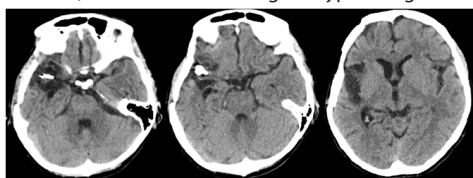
Axial noncontrast-enhanced computed tomography (CT) shows satisfactory finding one year later (Department of Neurosurgery, Cantonal Hospital Zenica, 2017)
